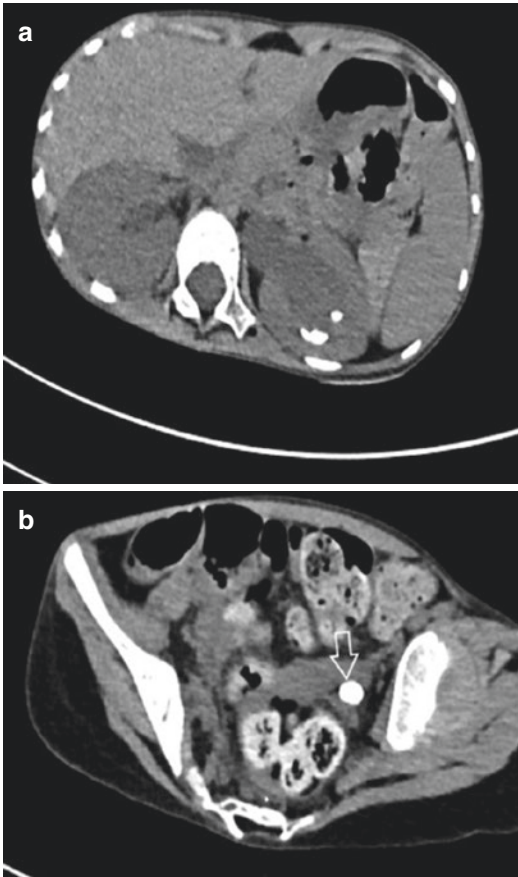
Multiple left urolithiasis with obstructing left ureter lithiasis—Unenhanced CT work-up. (a) Axial view of the kidneys. The left pyelocaliceal system appears dilated with two lithiases in the dependent calices. (b) Axial view of the lower abdomen a large lithiasis is obvious
